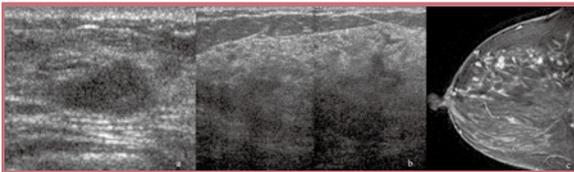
ductal carcinoma in situ. a, mass-forming DCIS showing features of benignity such as horizontal orientation and lack of acoustic shadowing. b, thickened ducts on sonography. c, same tumour on MRI with clumped branching enhancements typical of DCIS.
